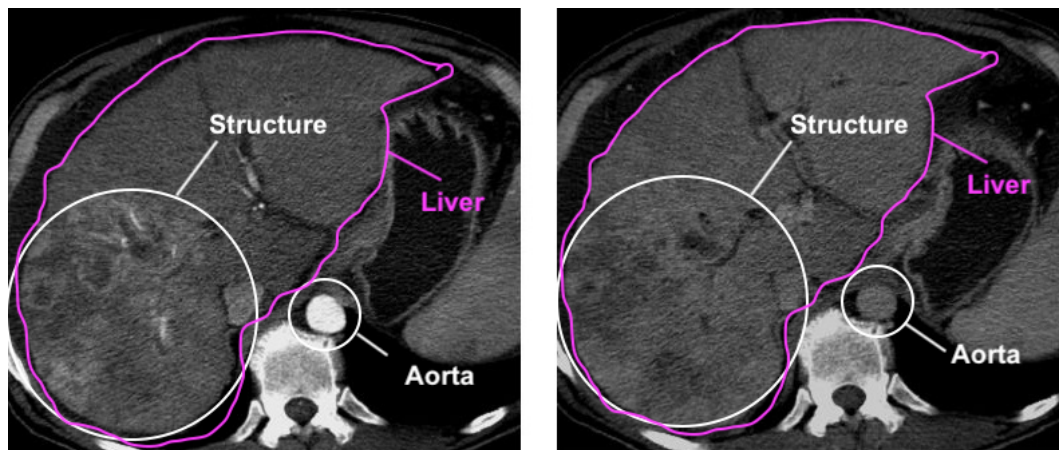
Arterial and Venous Phase of an abdomen CT – created by Kristie Guite, Louis Hinshaw and Fred Lee [25] and Mikael Häggström, MD released under the Creative Commons Attribution 3.0 Unported License [26] used with permission, labels added by Gerald Wagner
